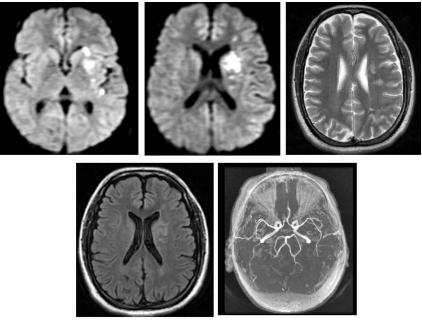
T2 & FLAIR hyperintensities in left basal ganglia and parietal region – s/o acute infarct. MRA normal.
